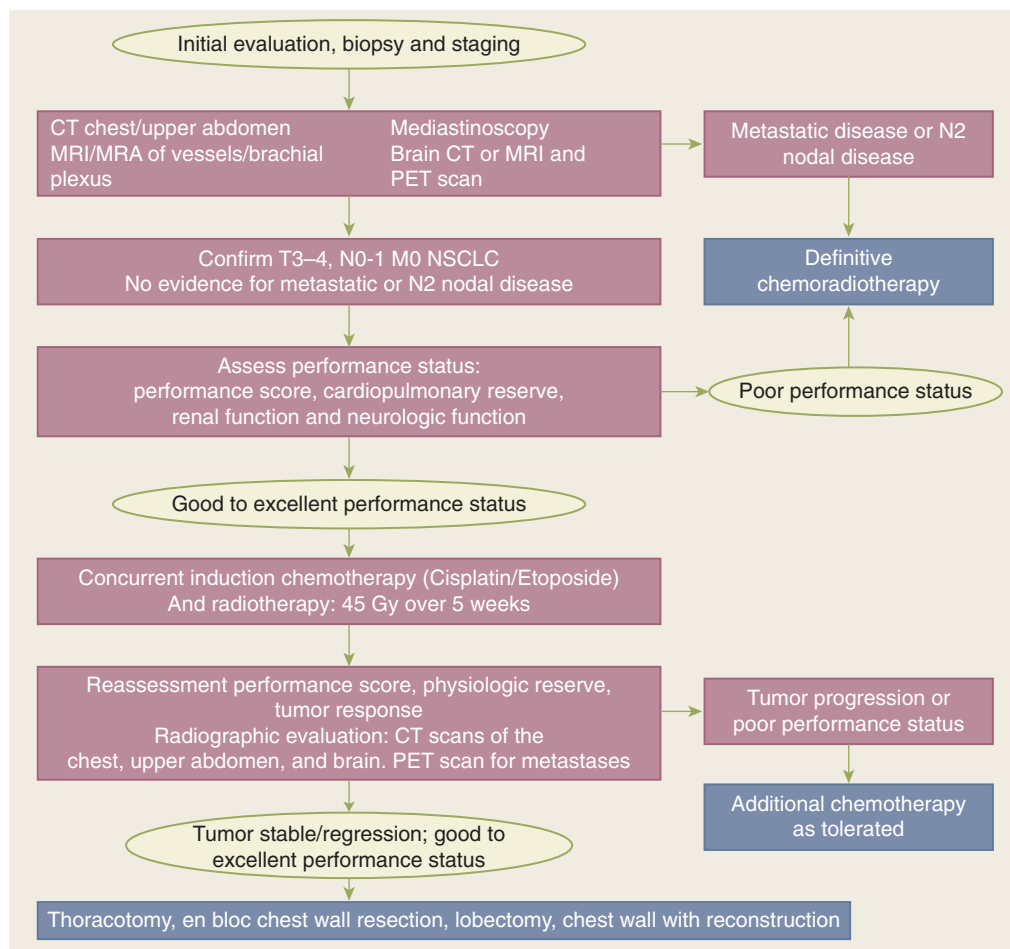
Treatment algorithm for Pancoast's tumors. CT = computed tomography; MRA = magnetic resonance angiography; MRI = magnetic resonance imaging; NSCLC = non-small cell lung cancer; PET = positron emission tomography.
